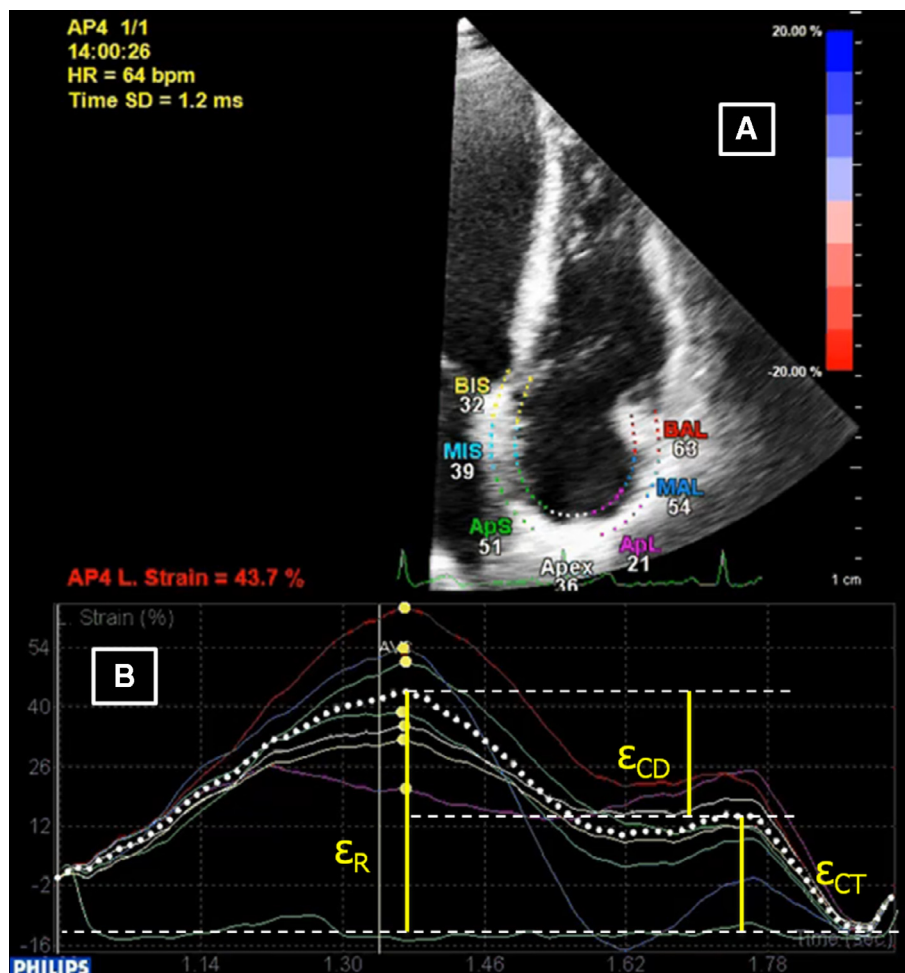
Speckle tracking analysis of RA strain: 4-chamber view depicting the region of interest created by the speckle tracking software (A). The global strain curve (dashed line) is obtained after averaging the seven regional strain curves (B). (ϵ_R : reservoir strain; ϵ_{CT} : contractile strain; ϵ_{CD} : conduit strain.)
